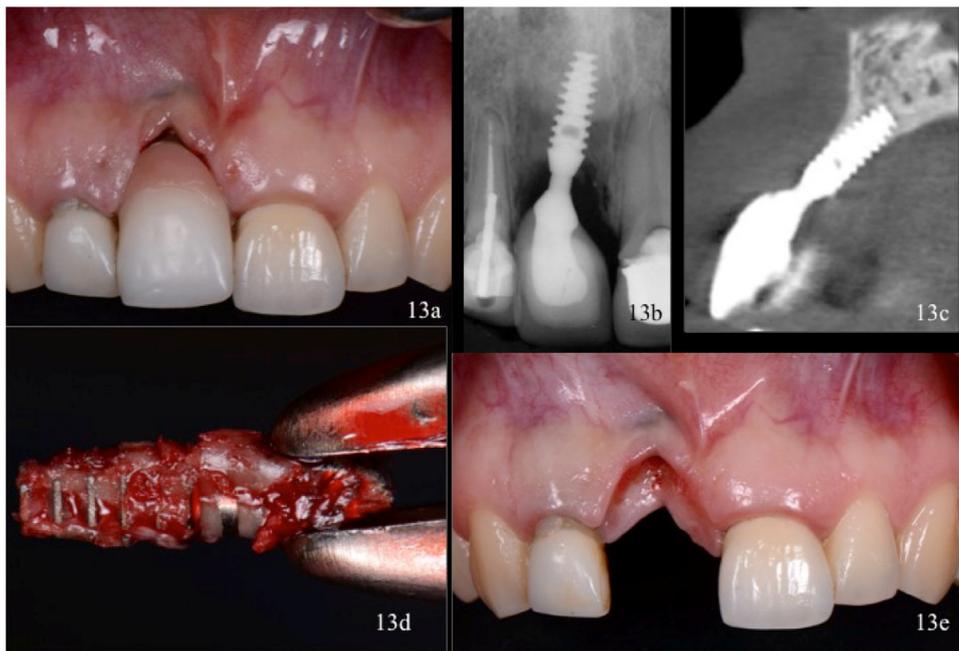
a. Clinical view of a peri-implantitis affected plateau dental implant with unsatisfactory aesthetics. b. Periapical radiograph of a peri-implantitis affected dental implant. c. CT-scan image demonstrating bone loss buccally and palatally. d. A trephine bur was used to separate the implant-to-bone contact and the implant was gently luxated and removed with a pair of forceps. e. Extensive hard and soft tissue defects following implant removal.
